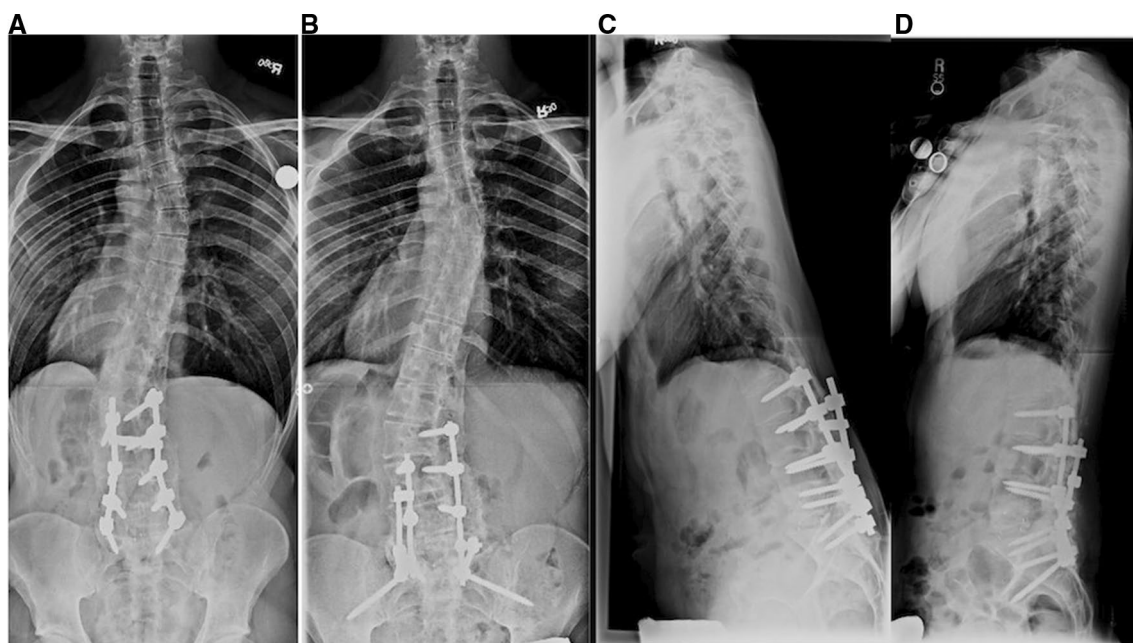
Radiographs of a 27-year-old man with an extended PSO at L5. The patient presented with severe sagittal imbalance. He had a history of scoliosis, which was treated elsewhere with instrumented posterior spinal fusion to L4. He developed distal junctional kyphosis, and although the fusion construct was extended to the sacrum with interbody fusion at L5–S1, rigid lumbosacral deformity
